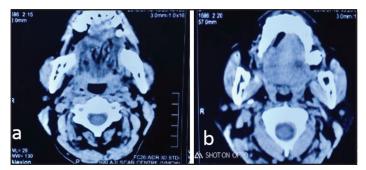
(a and b) Axial view of mandibular CT reveals well-defined hypodense lesion measures 31x 16 mm in the right sublingual space involving the floor of the mouth pushing the anterior genioglossus muscle to the left. No adjacent mandibular erosion was found.
